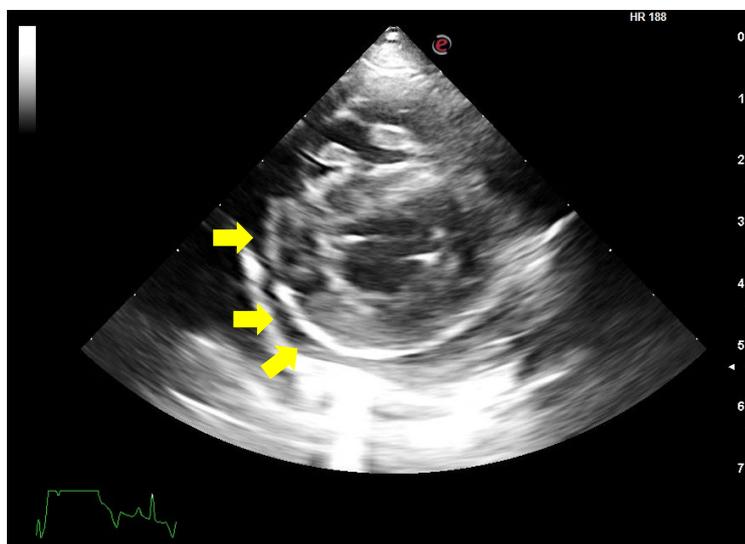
Right parasternal short axis view showing septal flattening of the left ventricle during the systole. Mild collection of pericardial fluid (arrows) was also appreciable.
